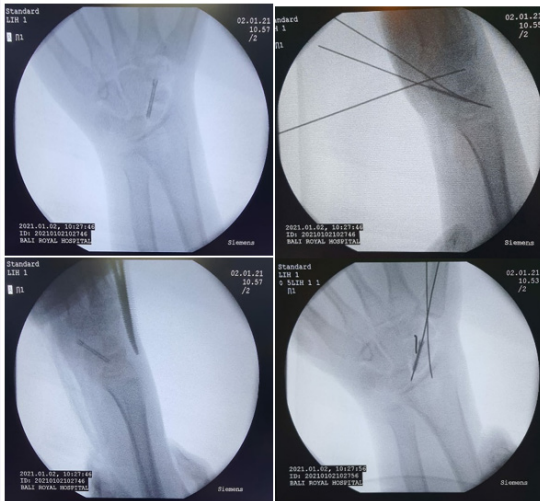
Radiograph after surgery
